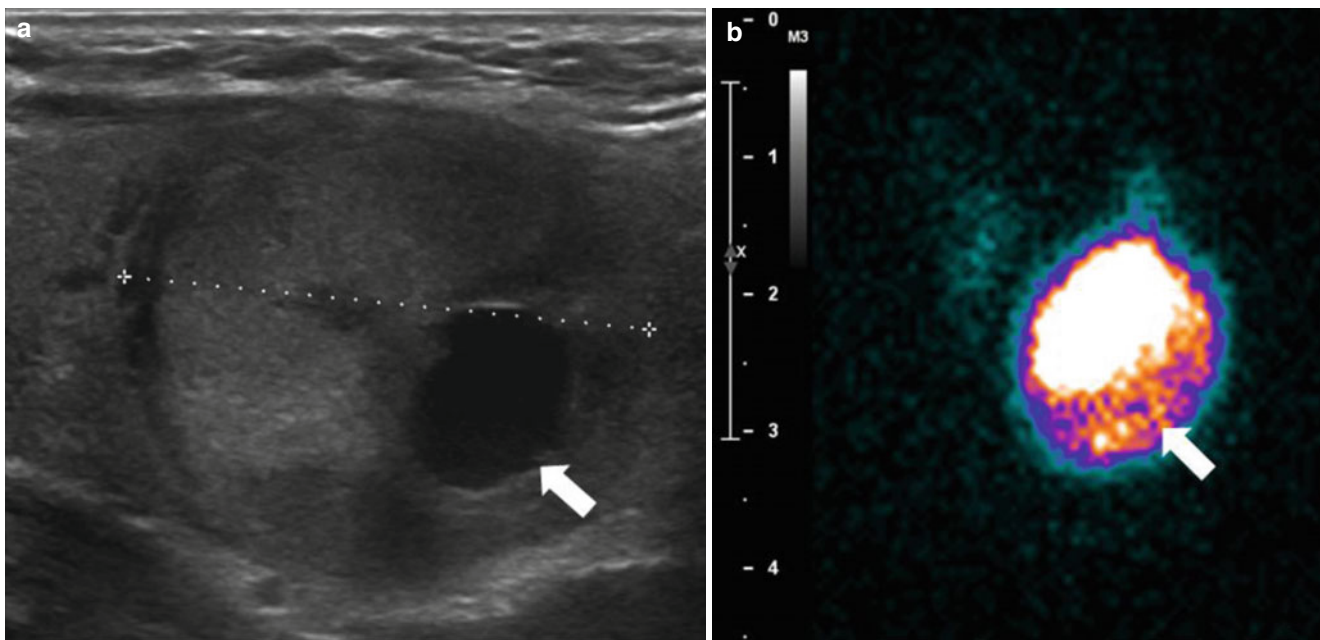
Sagittal ultrasound (a) and planar anterior ^{123}I scintigraphy (b) of a hyperfunctioning nodule (adenoma) of the left thyroid gland in a patient presenting with hyperthyroidism. Note the nearly complete functional
